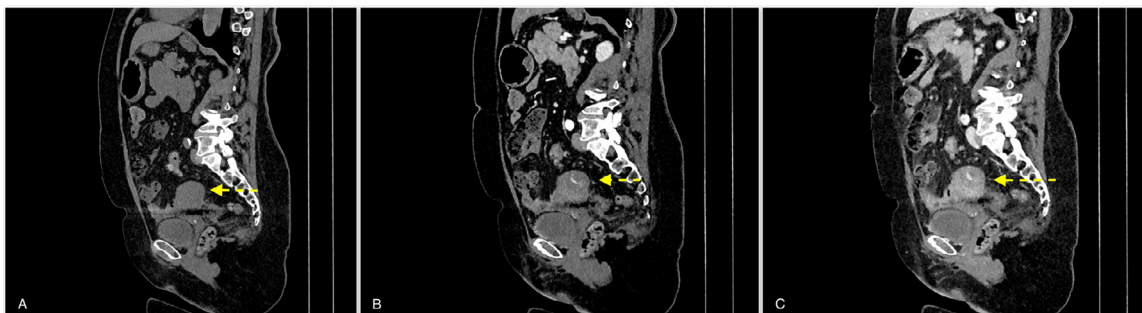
(A-C). Sagittal unenhanced phase (A), arterial phase (B) and portal venous (C) phase CT images show a focal and tiny area of blush at level the uterine fundus, compatible with vascular injury; The absence of hyperattenuating material on noncontrast images (A) (yellow arrow) in the same location of contrast extravasation on postcontrast images (B, C) (yellow arrows) helped us to confirm active bleeding. This finding was not appreciated at exploratory laparotomy.
